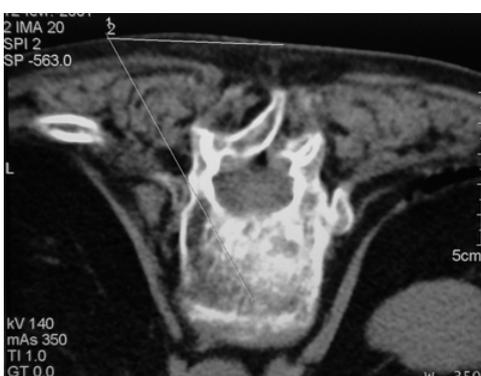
Preoperative CT-scan determines the entry point.
